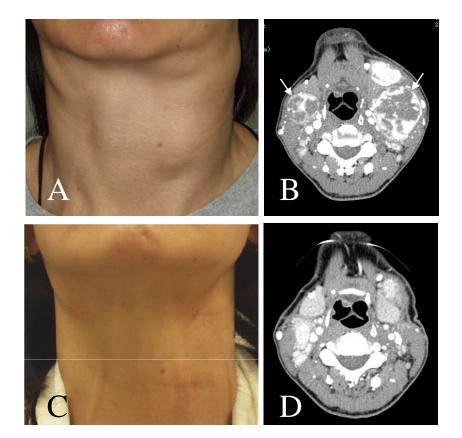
The patient showed nodular swelling in the bilateral neck but mainly on the left side (A), confirmed as enlarged lymph nodes with centrally located non-enhanced areas on computed tomography (B, arrows). Three months after surgical removal of these lymph nodes there was no apparent recurrence (C, D).
